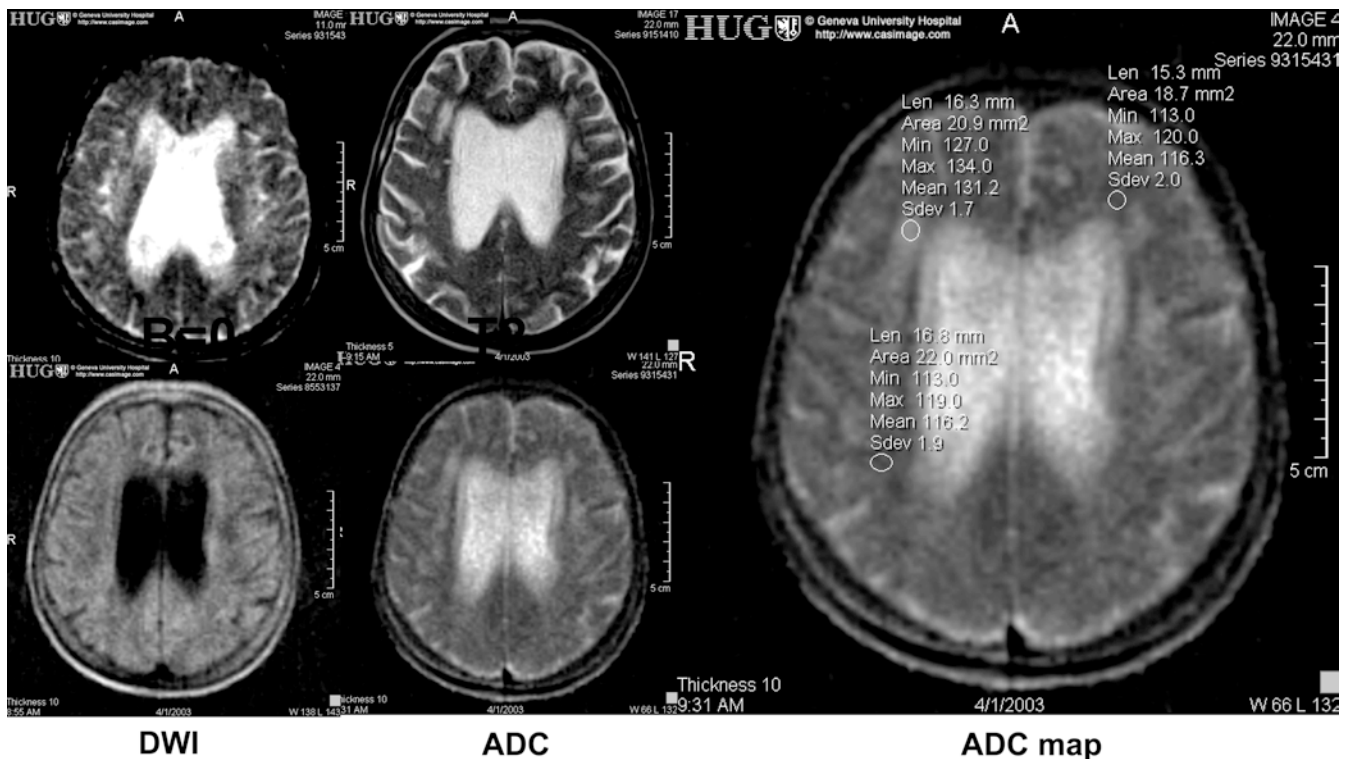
An 83-year-old woman with recent development of cognitive changes: the T2-weighted images in the upper left corner (*far left*: $b=0$ image; *middle*: T2-weighted spin-echo image) demonstrate frontal leukoariosis with little atrophy. The DWI image shows no acute stroke (*far left*) and the calculated ADC map again shows the bifrontal hyperintensities in the same areas. When measuring ADC measurements we found that the highest values in the leukoariosis on the right ($1.31 \times 10^{-3} \text{ mm}^2/\text{s}$) showed mean values higher than in the non-affected normal brain either in the less affected left hemisphere ($1.16 \times 10^{-3} \text{ mm}^2/\text{s}$) or in the parietal white matter ($1.16 \times 10^{-3} \text{ mm}^2/\text{s}$)
